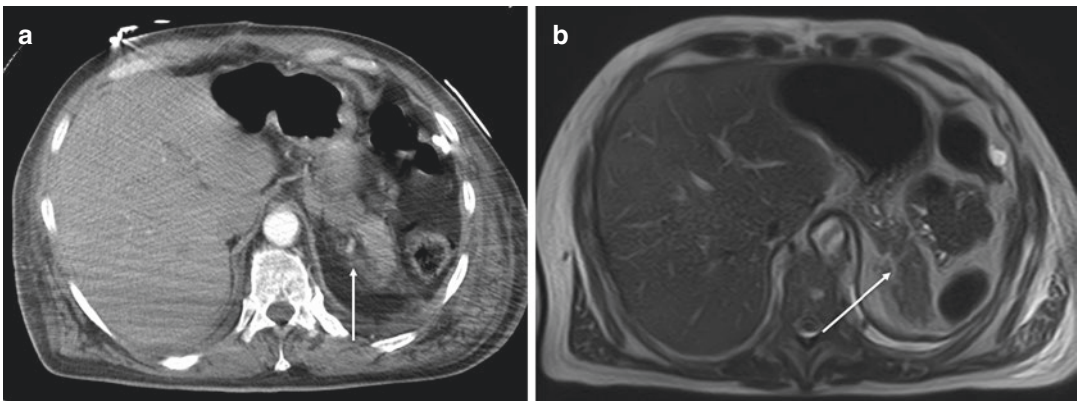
Pancreatic tail injury. The enhanced CT scan (a) shows the pancreatic tail enlargement, with inhomogeneous enhancement and a subtle peripancreatic fluid collection (arrow). (b) One week later, the follow-up
